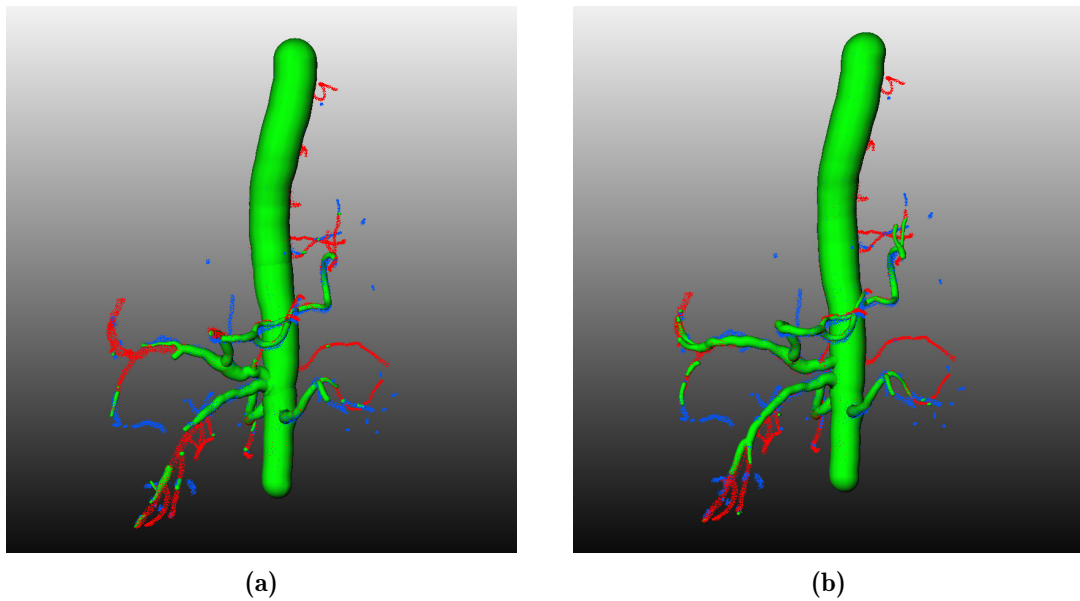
Segmentation by the U-Nets trained on (a) a real data set and (b) combined data set of both real and synthetic CT images. Green indicates where the segmentation matches the GT, red indicates false negatives and blue false positives. Reprinted by permission from Springer Nature Customer Service Centre GmbH: Springer Nature International Journal of Computer Assisted Radiology and Surgery ©2019.
